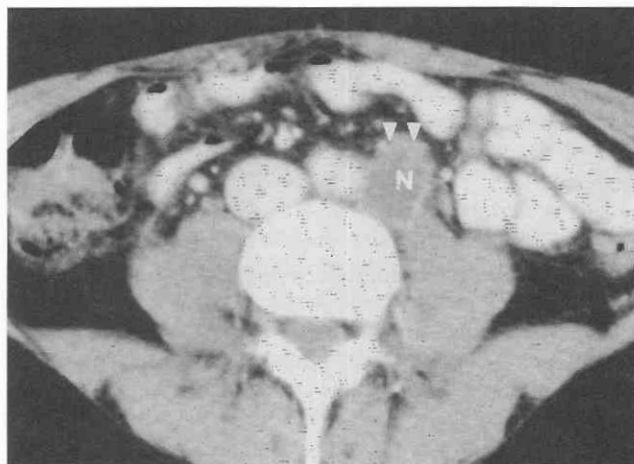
Metastatic cervical cancer. CT scan through the lower retroperitoneum shows a left para-aortic nodal metastasis (N) from cervical cancer having an irregular enhancing margin (*arrowheads*) and central necrosis. Such margins predict extra-nodal tumor extension.
